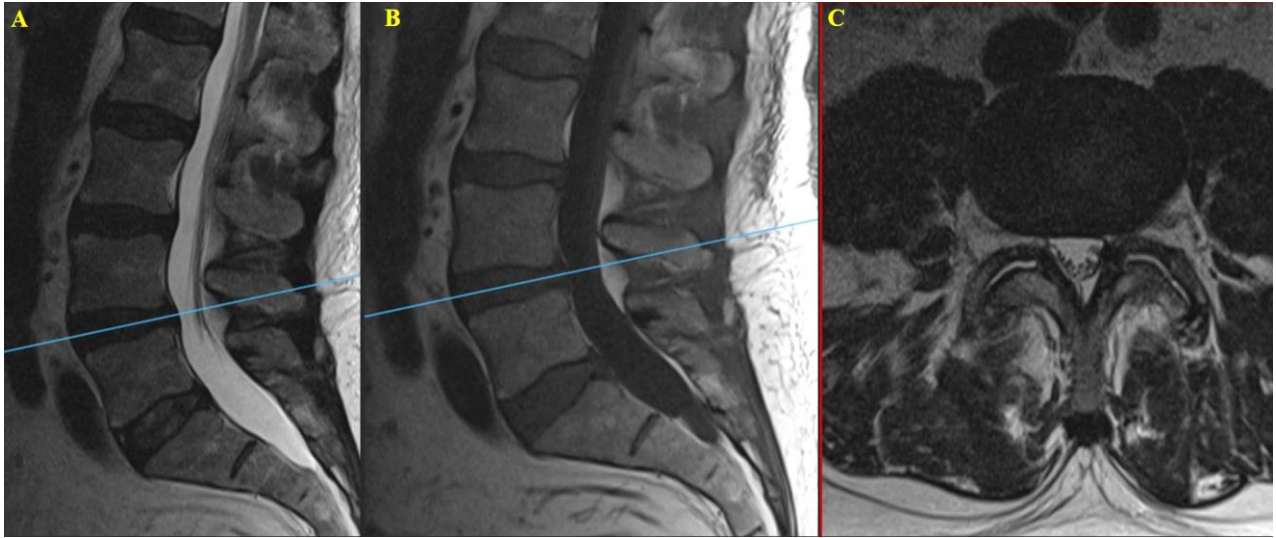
Sagittal T2-weighted (A), Sagittal T1-weighted (B) and axial T2-weighted magnetic resonance imaging of the lumbar spine before the development of bilateral facet cyst.
